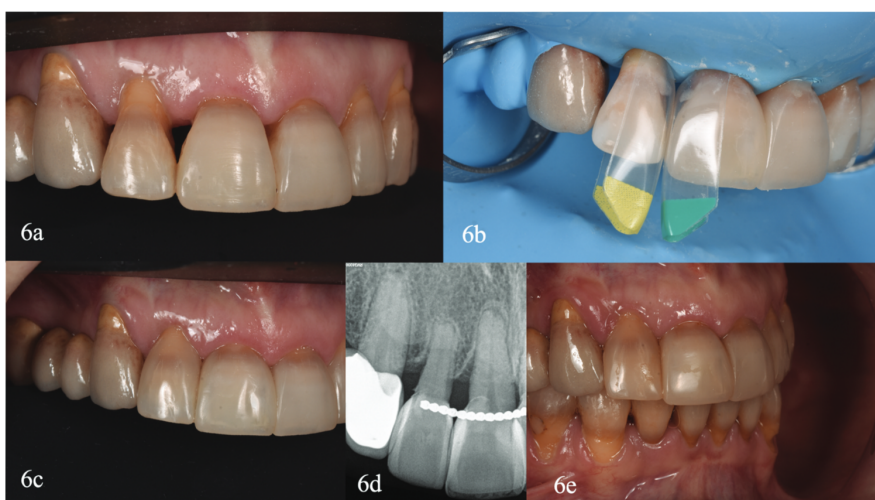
Clinical case IV. (a) Initial intraoral lateral view. (b) Detail of the isolated teeth. The largest yellow and green specific matrices for black triangles were selected (black triangle kit. Bioclear matrix systems. Bioclear). (c) Two weeks clinical control (d) Radiographic control at two weeks. (e) Two years review, highlighting the restoration integrity.
